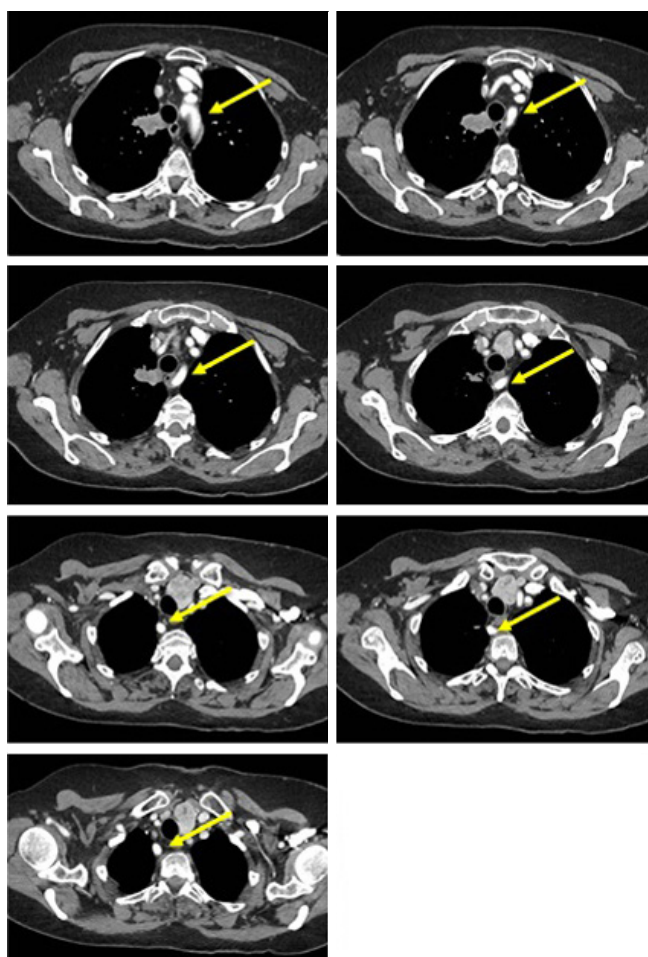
CT of the mediastinal window, showing the course of the right aberrant brachiocephalic artery as it branches off the aorta from the left side, crossing the midline posterior to the oesophagus to supply the right upper limb (yellow arrow).
